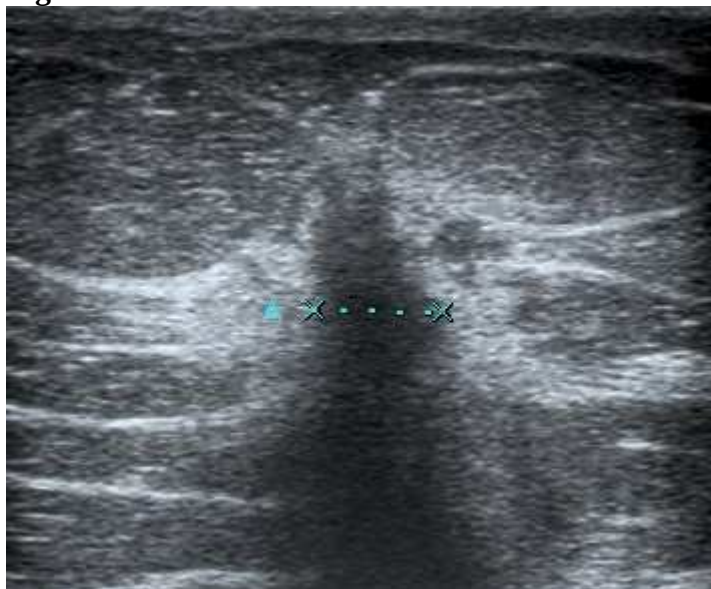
breast carcinoma on US and MRI
